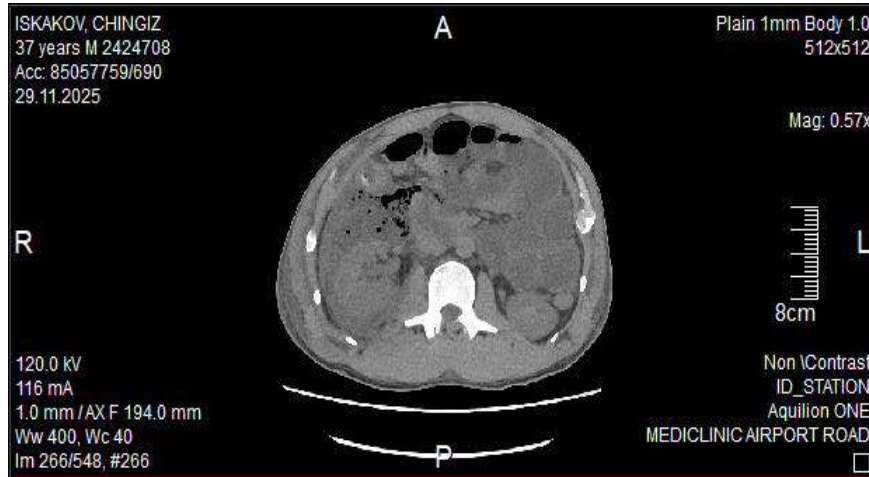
Axial unenhanced CT (Mediclinic Airport Road Hospital, 25 November 2025), 5 mm reconstruction. The right retroperitoneum is markedly thickened with multiple discrete locules of free air tracking along the right paracolic gutter, in keeping with viscus perforation; the duodenum and proximal small bowel are dilated and gas-filled.
